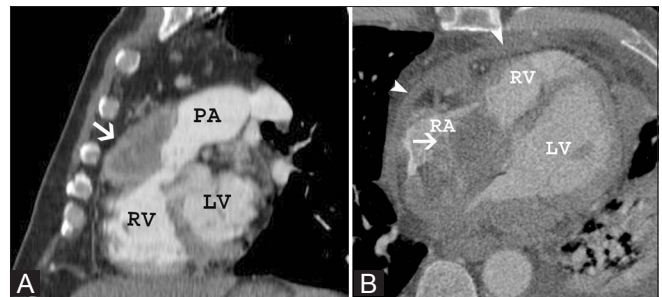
(A, B): Malignant tumors. Sagittal CT image (A) shows a heterogeneous infiltrative mass (arrow) anterior to the right ventricular outflow tract in a patient with prostate carcinoma; this is consistent with metastasis. Axial CT image (B) shows a large irregular mass (arrow) in the right atrium, extending through the tricuspid valve and left ventricle and associated with pericardial thickening and effusion (arrowhead). The mass has also extended into the left atrium
